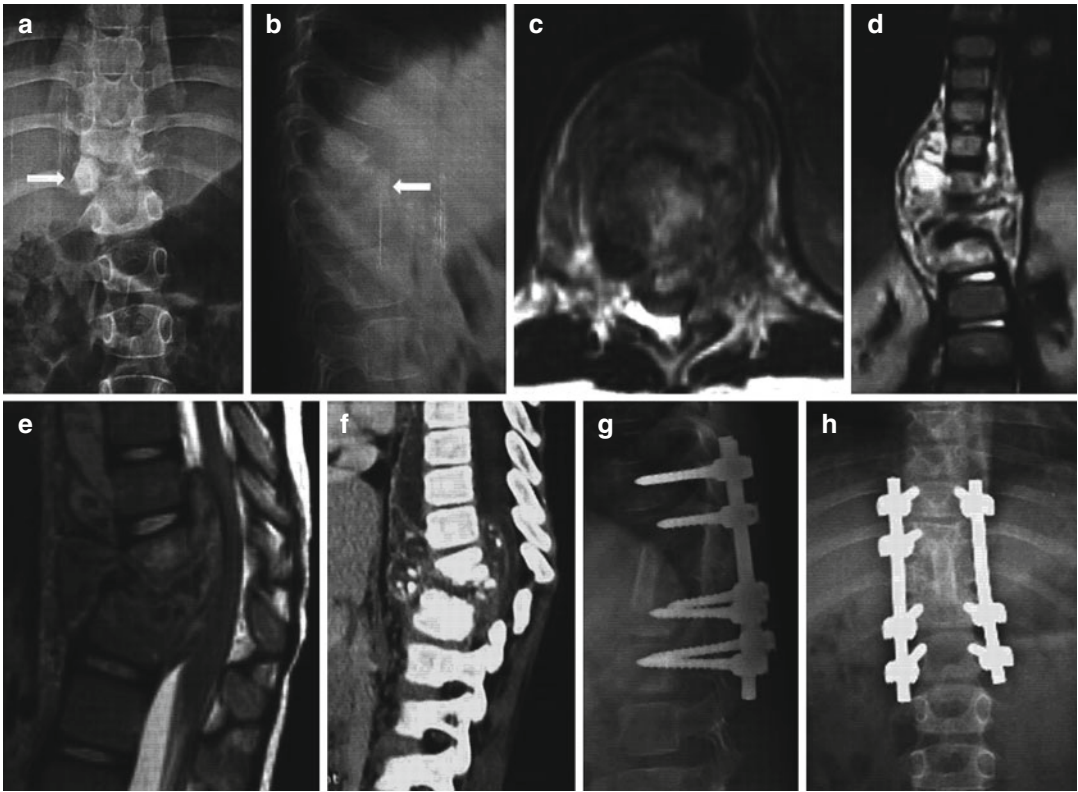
(a, b) This 9 year old child presented with T12-L1 tuberculosis and paraplegia seen in the radiographs as vertebral collapse and local kyphosis (*white arrows*). The MR images (c-e) shows extensive abscess formation in the perivertebral space, epidural abscess, cord compression and multiple vertebral destruction. The
